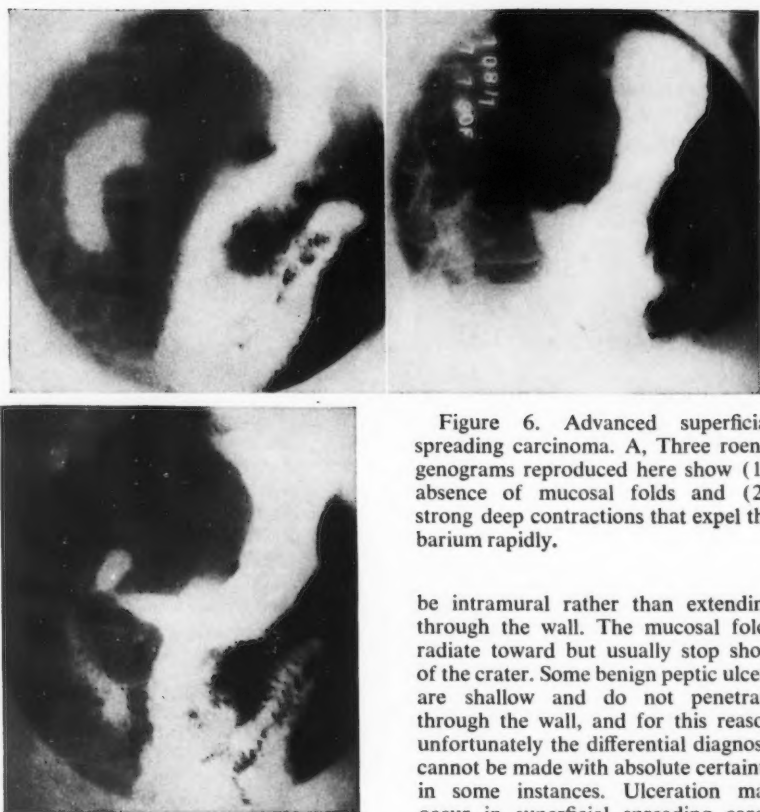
Advanced superficial spreading carcinoma. A, Three roentgenograms reproduced here show (1) absence of mucosal folds and (2) strong deep contractions that expel the barium rapidly.
